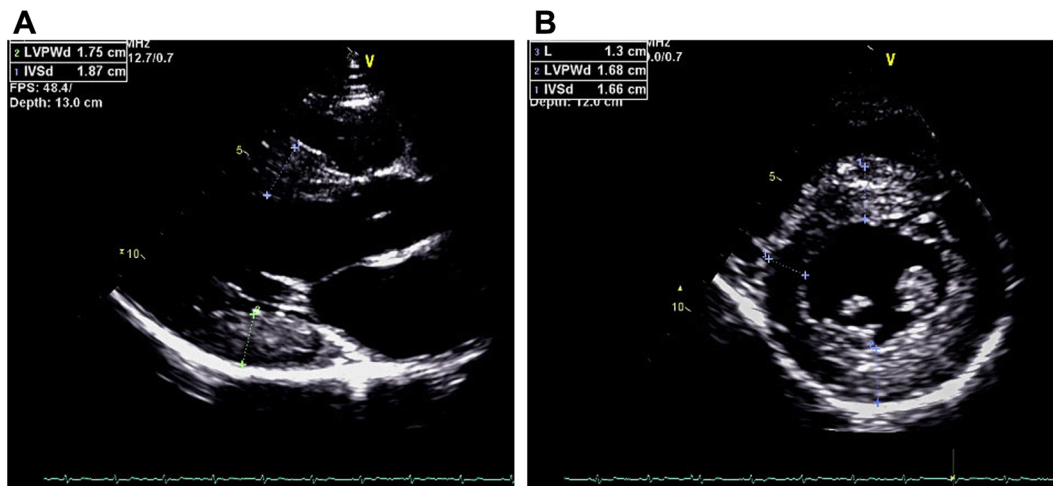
Baseline transthoracic echocardiogram demonstrating concentric LV hypertrophy. (A) Interventricular septal thickness 18.7 mm, LV posterior wall thickness 17.5 mm. (B) Concentric hypertrophy.
